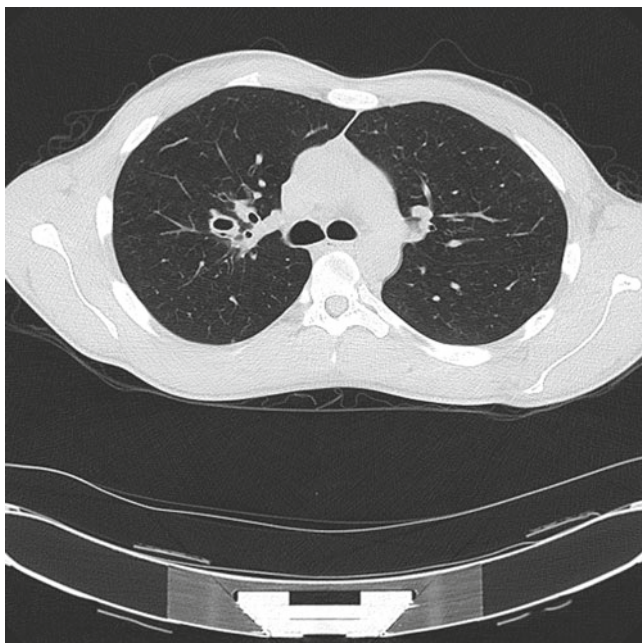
CT chest with circular lucent lesions with dense borders in the right perihilar region
